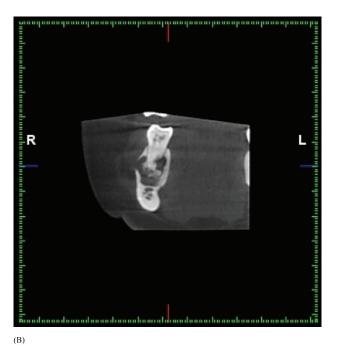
(A) 3D CBCT view of the COF. (B) Coronal view of CBCT image of the COF.
